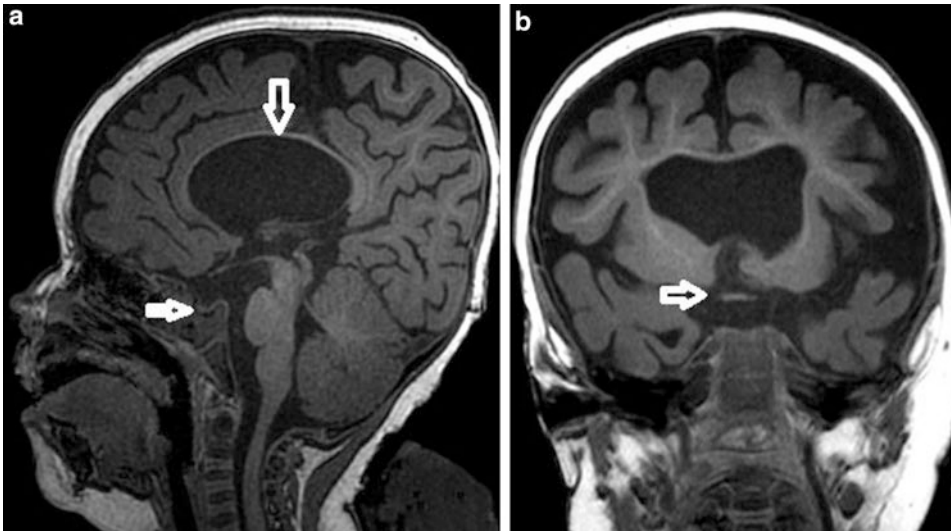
(a, b) A 9-month-old boy with a history of encephalopathy and epilepsy. The molecular genetic study identified a 143 kilobyte interstitial duplication of an Xp11.4. MRI of the brain demonstrates the complete absence of the septum pellucidum with ventriculomegaly and white matter thinning. There is absence of the normal posterior
